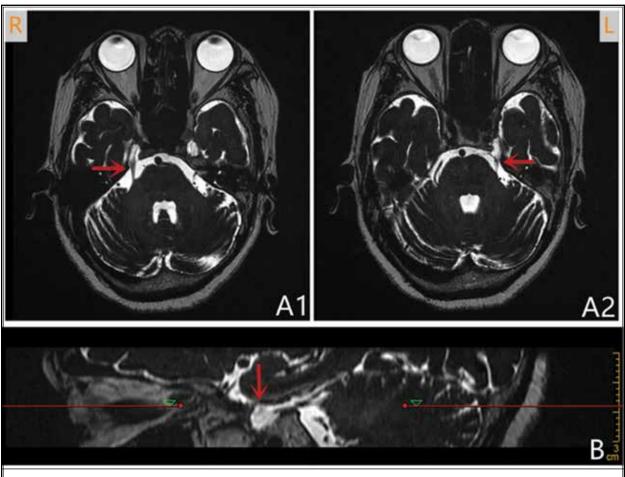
Functional magnetic resonance imaging of the trigeminal nerve. A1. The contralateral trigeminal nerve; A2. The affected trigeminal nerve compressed by blood vessels; B. The Meckel's cavity (sagittal plane).
